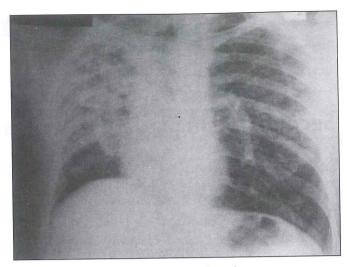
Bilateral infiltrations of case chest radiography
